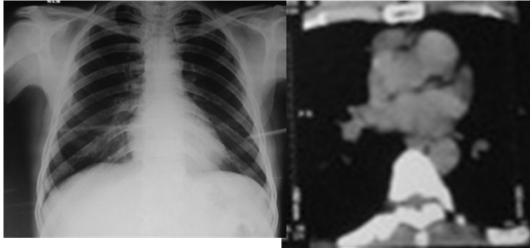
Patient 4: 54M- Type A- the SOL is small and no invasion on CT and it correlates with HPE
